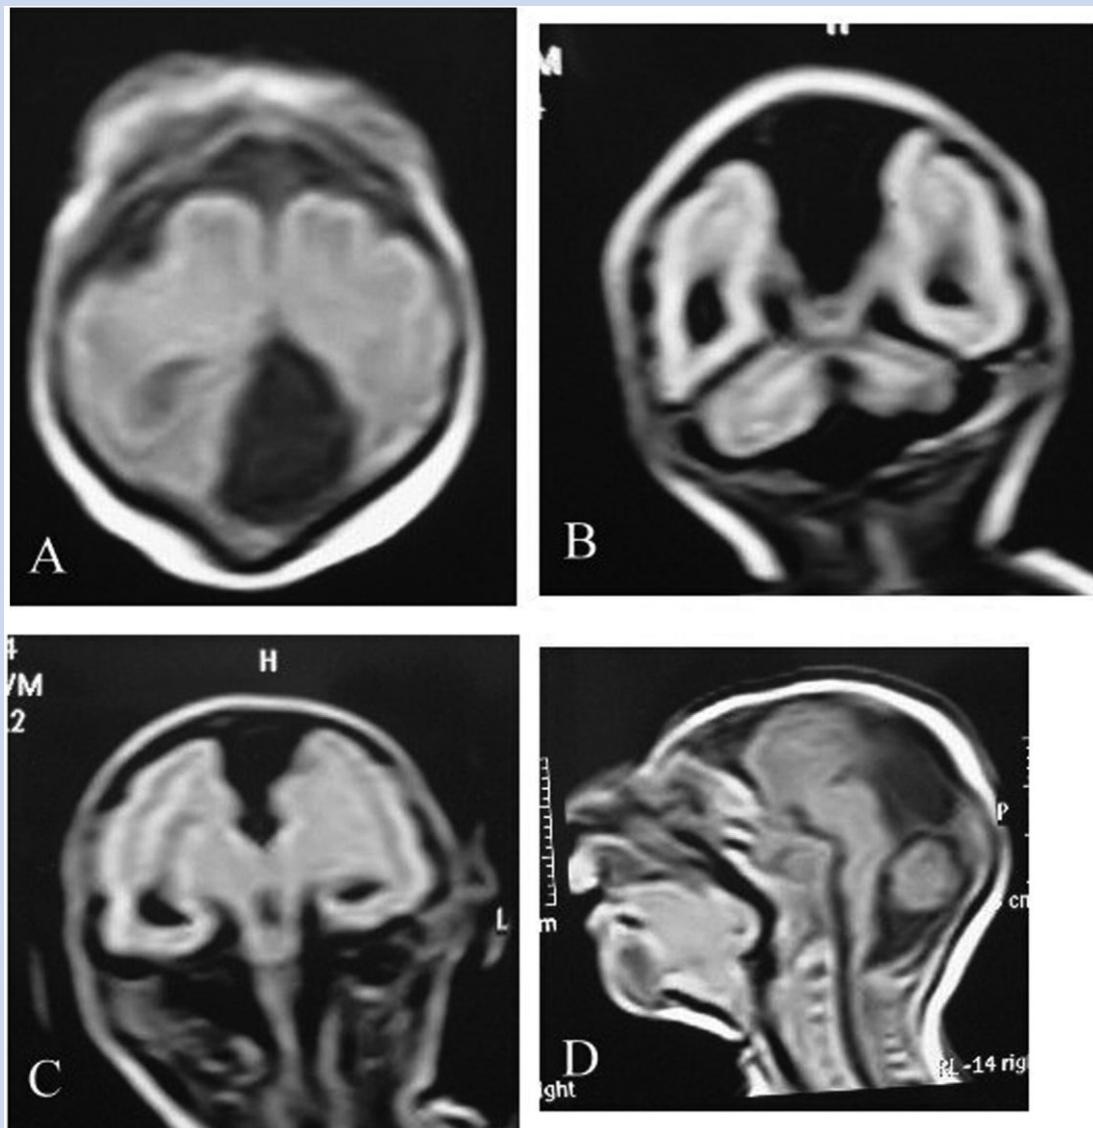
Brain MRI of Patient 1 showing (A) axial view of abnormal gyral pattern, (B) coronal view with interhemispheric cyst and hypoplastic cerebellum, (C) abnormal hippocampus, (D) sagittal view showing agenesis of corpus callosum, hypoplastic vermis and pons but of proportionate size to the small cerebral hemispheres.
